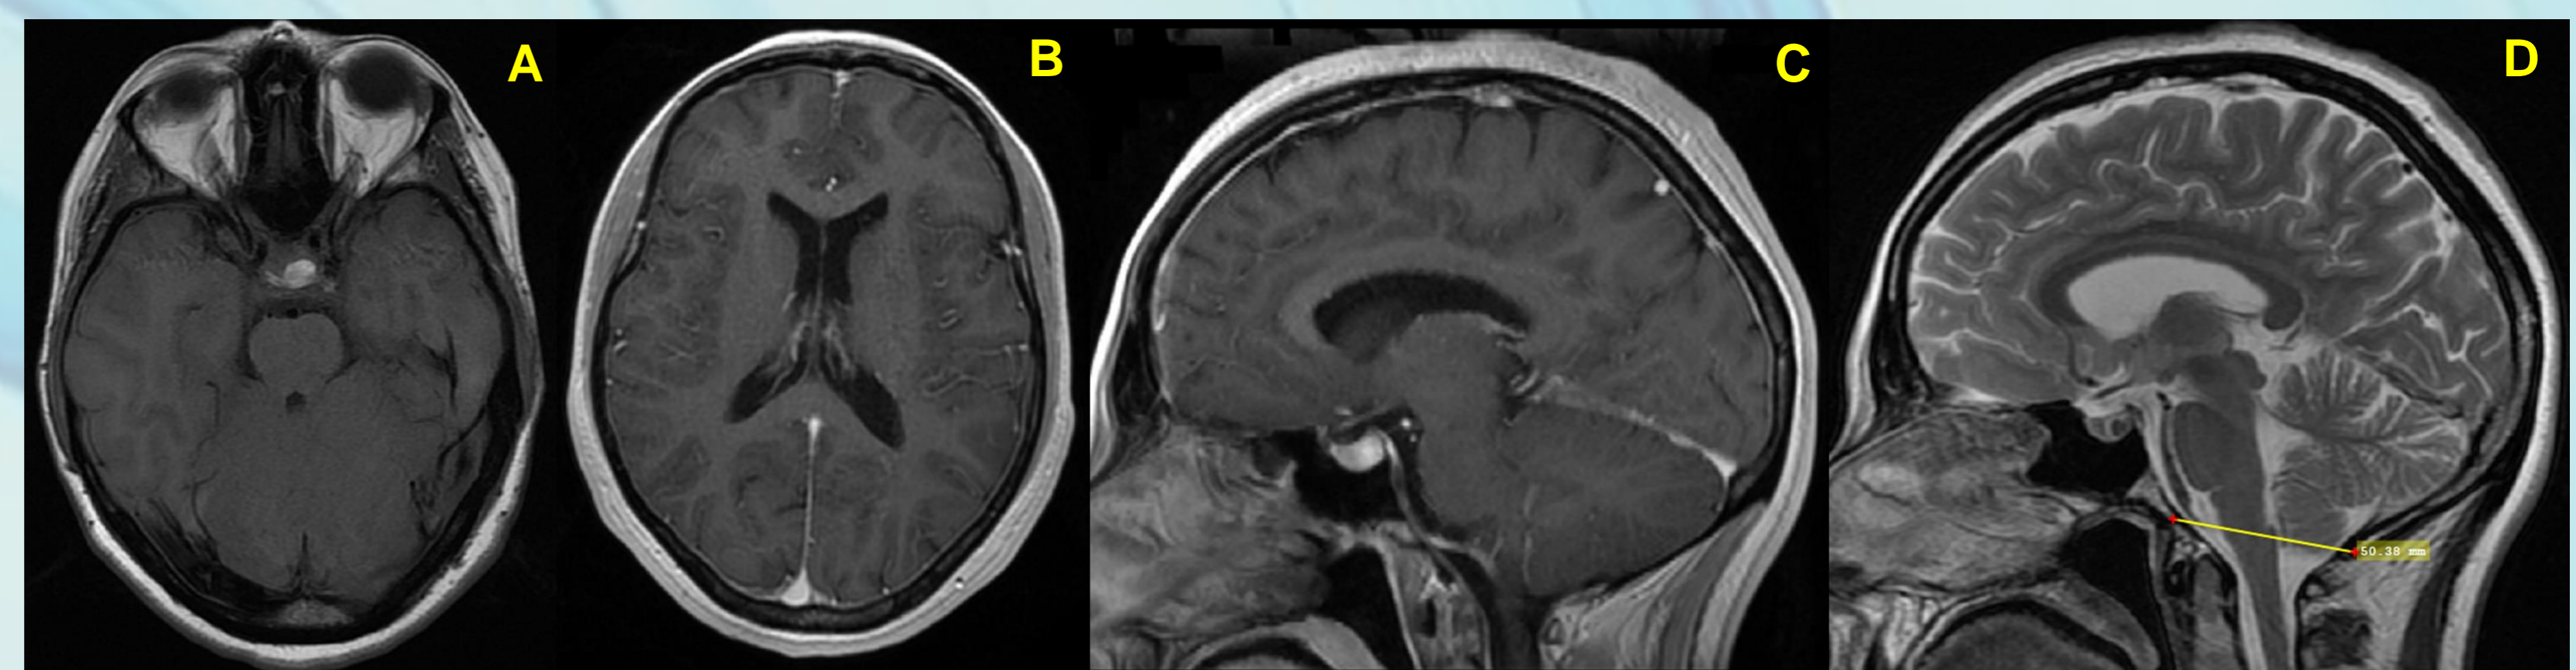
A) T1 weighted image; B-C) axial and sagittal T1 post contrast images; D) sagittal T2-weighted image
